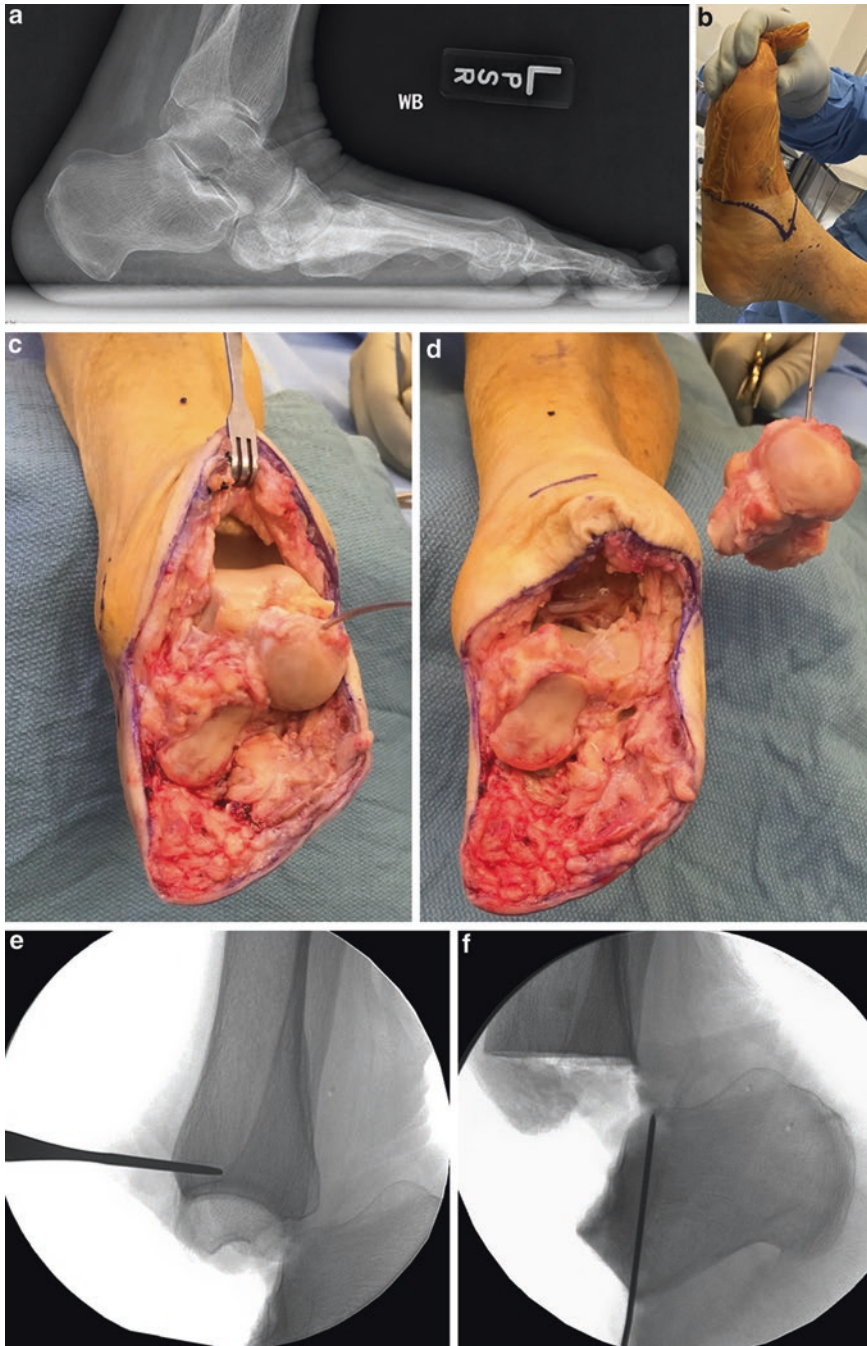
Pirogoff amputation. (a) Preoperative x-ray showing midfoot collapse and deformity. (b–d) Intraoperative pictures showing the incision, disarticulation through the transverse tarsal joint, and resection of the talus. (e, f) Intraoperative fluoroscopic images showing the osteotomies
